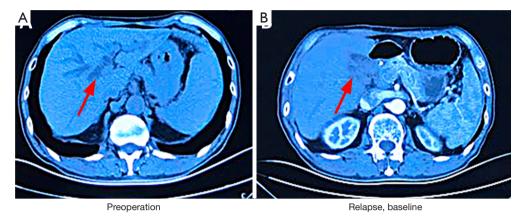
Abdominal computed tomography (CT). (A) Preoperation: CT revealed intrahepatic bile duct dilatation, obstruction at the hepatic hilar region proximal to the common hepatic duct, and splenomegaly (arrow). (B) Baseline: abdominal CT revealed local recurrence: hepatic hilar mass, involving the hepatic artery and portal vein, and dilated bile duct in the hepatic hilum and left lobe of the liver (arrow).
